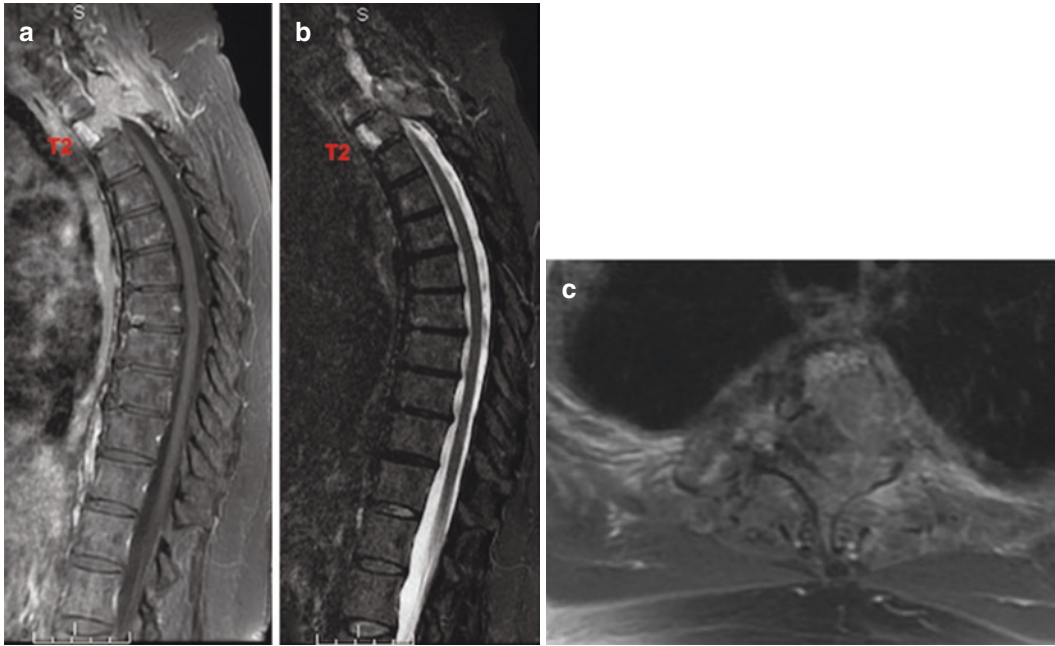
(a) A 64-year-old EGFR+, non-small-cell lung cancer patient presents with severe back pain, leg weakness 3/5, inability to ambulate, and severe spinal cord compression. The patient previously underwent radiation to the thoracic spine as well as the chest for lung cancer. (a) Preoperative MRI and sagittal T1 post-contrast demonstrate T2 pathologic fracture and high-grade spinal cord
